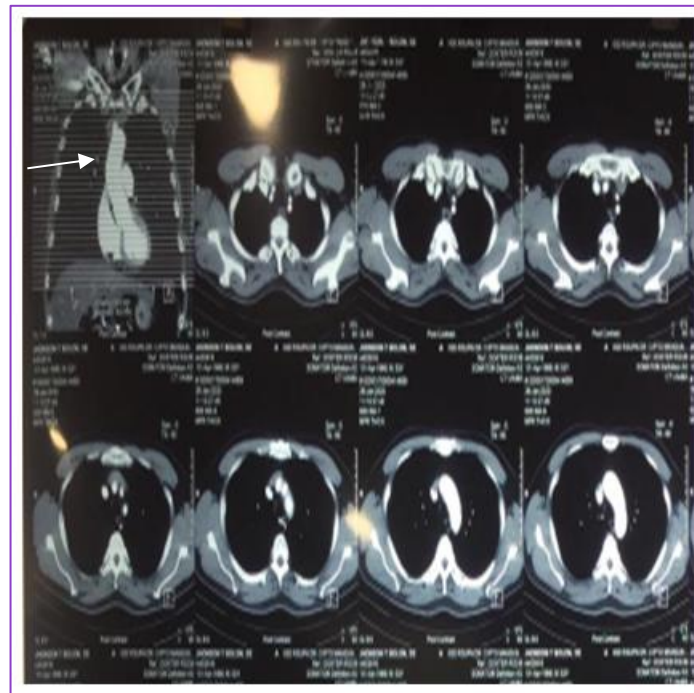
Thoracic CT scan with contrast
